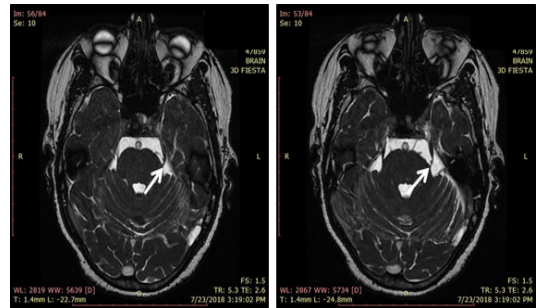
Axial T2 MRI images at the level of pons showing vascular loop compressing cisternal portion of left trigeminal nerve.
